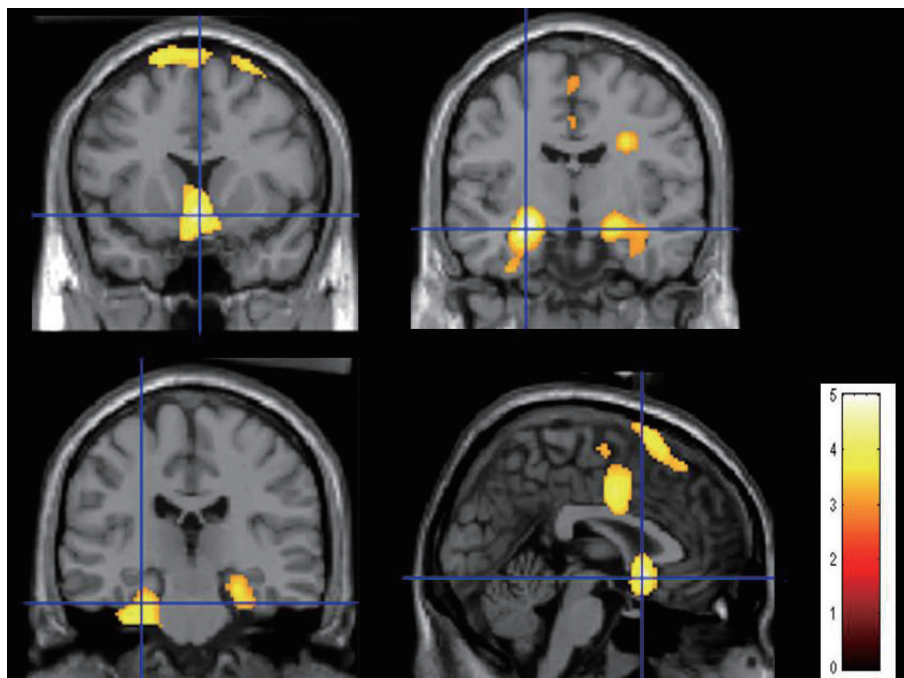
SPM results demonstrating brain regions with increased rCBF after methylphenidate treatment of narcolepsy patients. According to the SPM, overlaid on T1 MR images, methylphenidate treatment increased rCBF in the bilateral prefrontal and temporal cortices. SPM: statistical parametric mapping, rCBF: regional cerebral blood flow.
